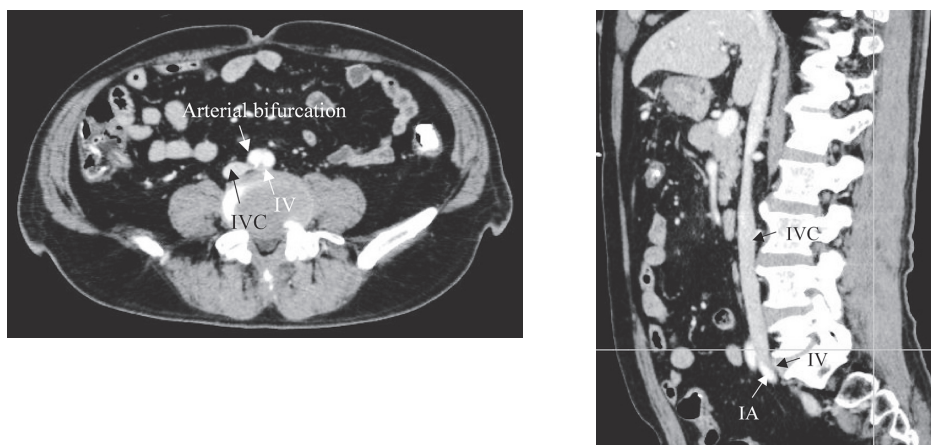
A coronal and sagittal CT of the level of the pelvic inlet demonstrated the compression of the left iliac vein (IV) by the right iliac artery (IA) and lumbar vertebra. At this time, the clot was not recognized to be in the iliofemoral vein.
